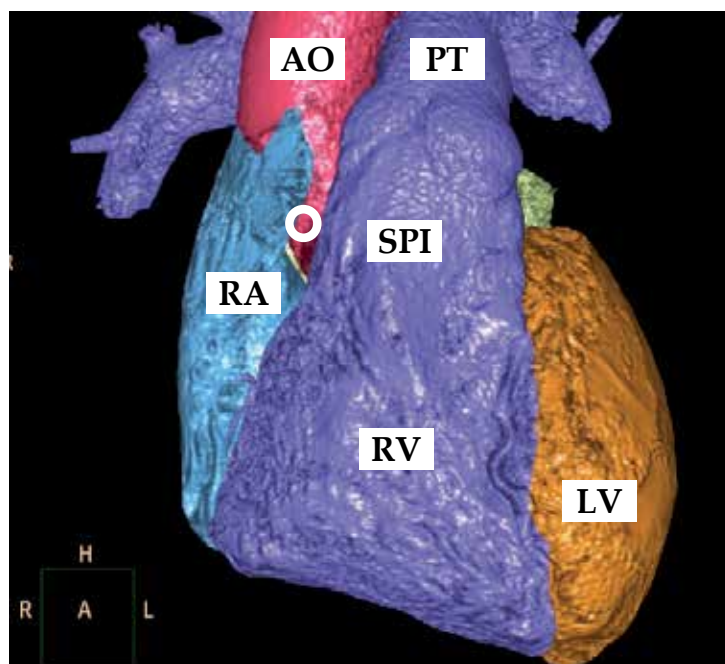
Volume-rendered computed tomography image of the heart with the normal origin of the right coronary artery (white circle) marked. AO: aorta, LV: left ventricle, PT: pulmonary trunk, RA: right atrium, RV: right ventricle, SPI: subpulmonary infundibulum.
